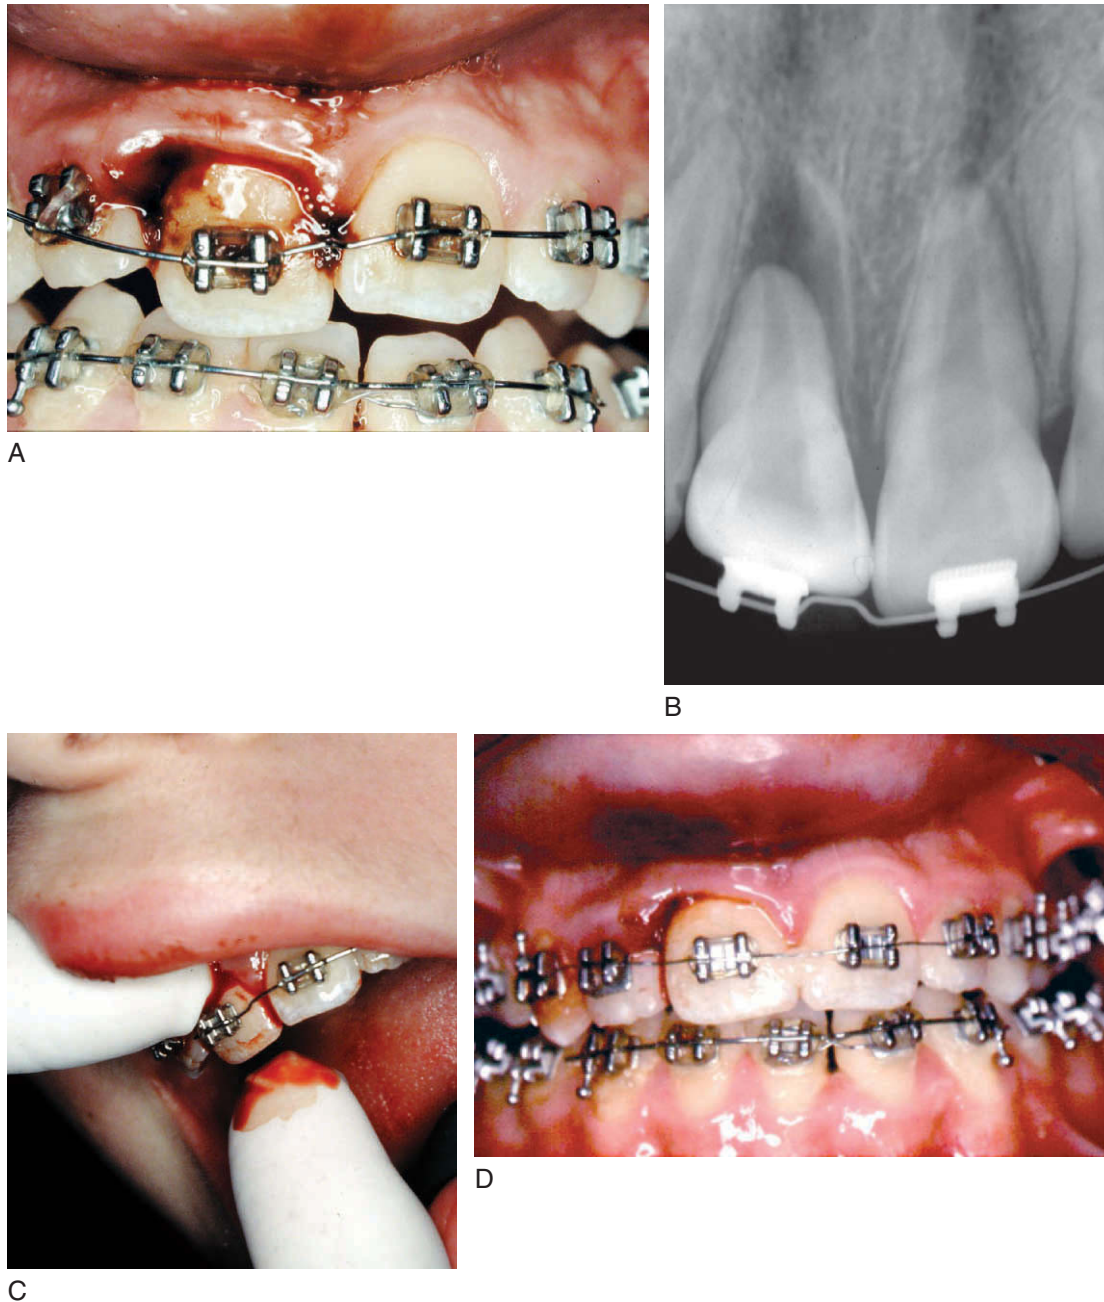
Lateral luxation with apical displacement of maxillary right central incisor. A, Observe occlusal interference from luxation. B, Radiographic appearance of displaced apical root from alveolus. C, Manual reduction of luxated tooth. D, Tooth in proper position and splinted. Note vestibular hematoma from alveolar fracture. *Continued*
